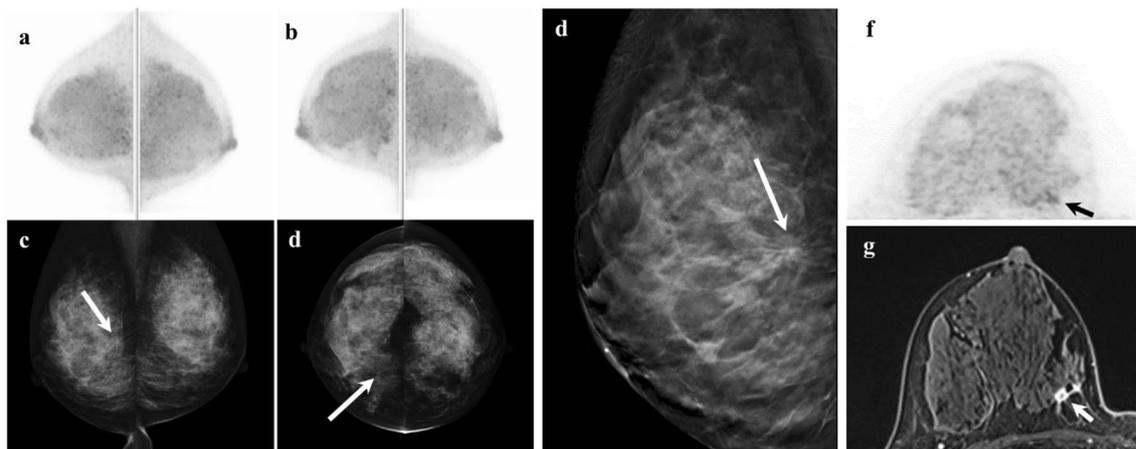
DbPET-negative invasive ductal carcinoma of the right breast (woman aged in 50 s). Pathological stage IA, luminal A subtype, nuclear grade 1, and Ki-67 2.2%. The mediolateral (ML) view and craniocaudal (CC) view of dbPET MIP (a, b) with the PET window intensity of SUV 0 to 4, mediolateral oblique (MLO) view and CC view of DM (c, d), the MLO view of DBT (e), axial dbPET image (f), and axial early-phase image of diagnostic MRI (g). No abnormal
